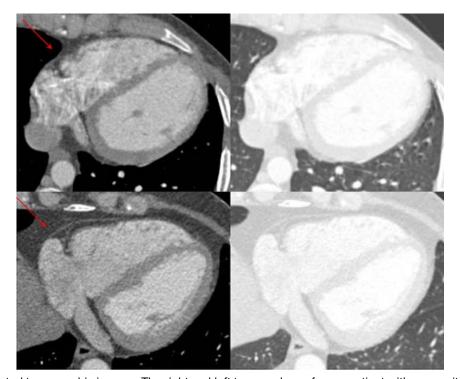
Axial computed tomographic images. The *right* and *left top* panels are from a patient with congenital absence of the pericardium. Characteristic interposition of lung tissue at the right (*red arrow*) and left atrioventricular groove is seen. (*Bottom*) A patient with an intact pericardium with the absence of this finding.
